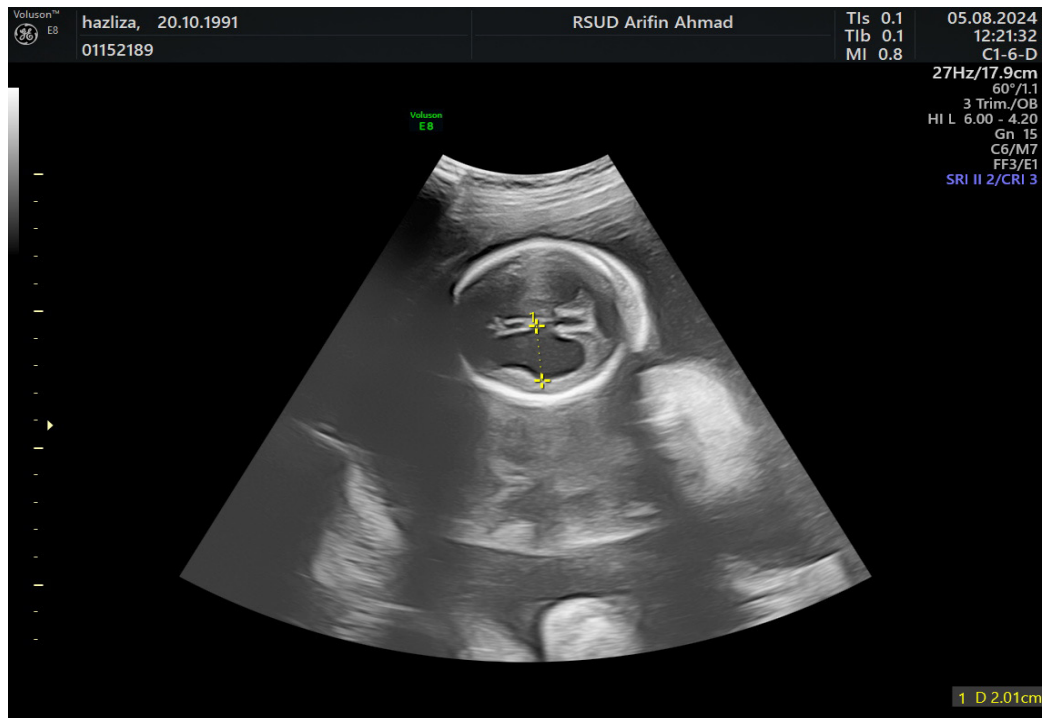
The first fetal ultrasound showed ventriculomegaly
